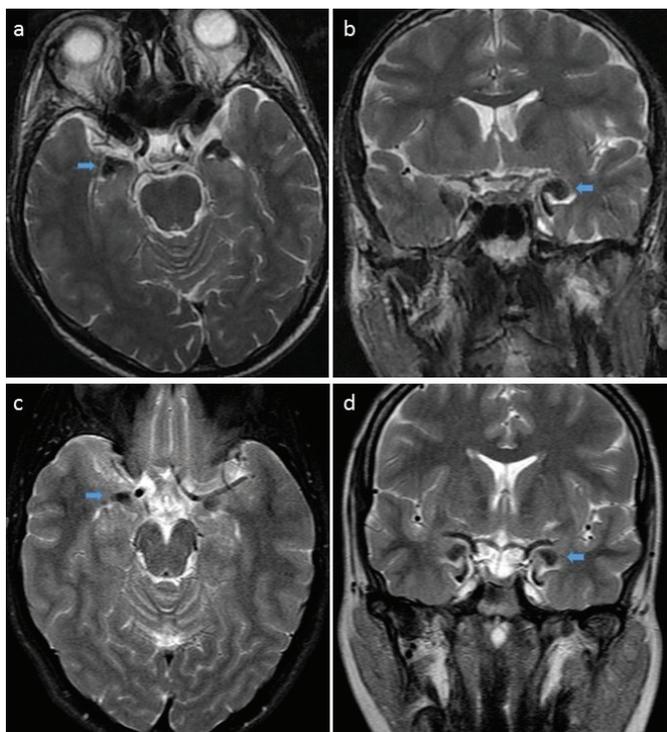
Magnetic resonance imaging images in two patients with lipid proteinosis. Bilateral symmetric bean shaped (arrows in a and b) and oval (arrows in c and d) calcifications in the uncus part of temporal lobes involving both the hippocampi were seen signal-free in the axial and coronal T2-weighted images which are pathognomonic radiological findings for this disease
